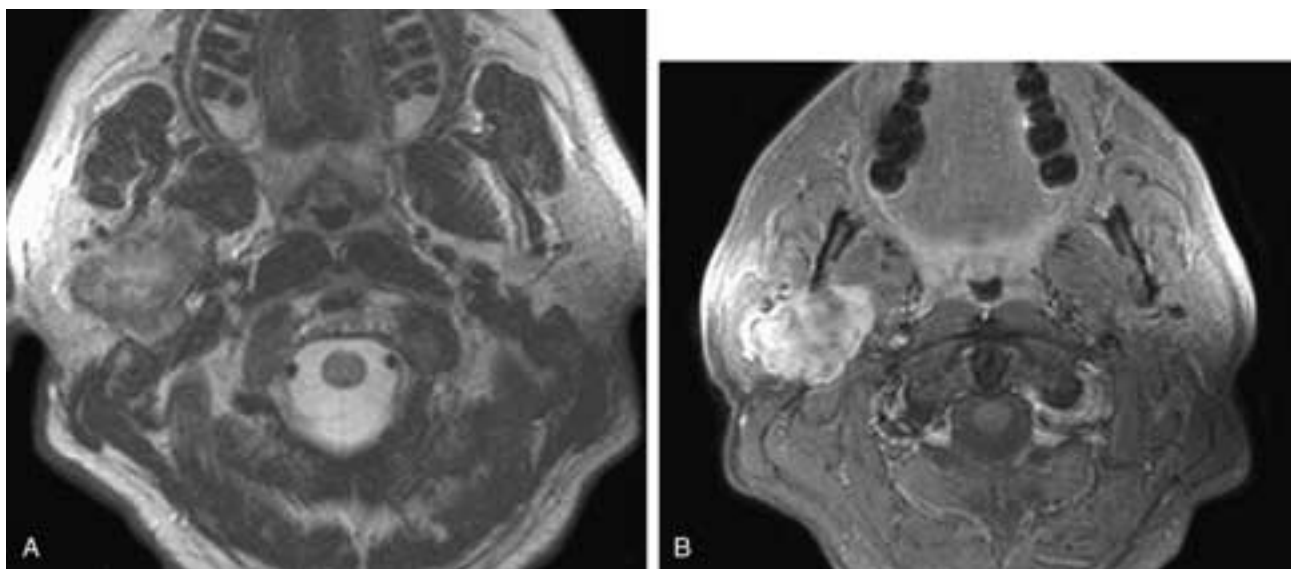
Axial T2-weighted MR image (A) shows a right deep parotid mass with slightly unsharp margins. The mass has a fairly low signal intensity. Axial T1-weighted, fat-suppressed, contrast-enhanced MR image (B) shows the mass to enhance nonhomogeneously. This was a carcinoma ex pleomorphic adenoma.
